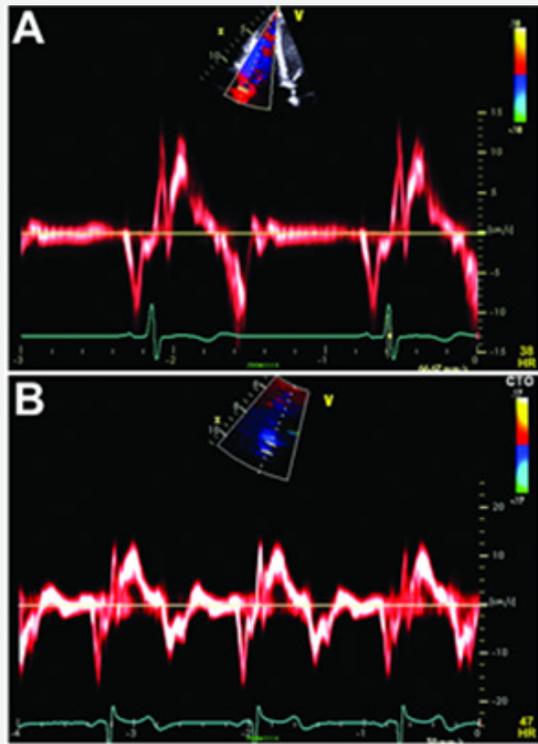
Right ventricular tissue Doppler in patient #1(A) and patient #2(B).
